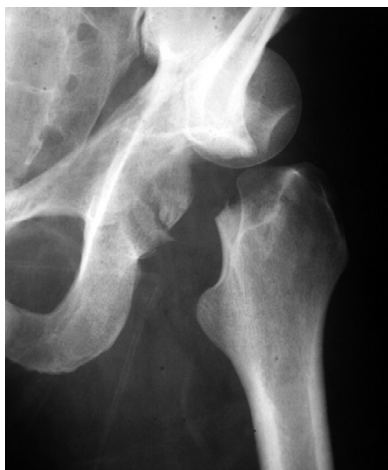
Anteroposterior plain radiograph showing the original severe fracture dislocation of the left hip prior to surgery. There is complete separation and displacement of the femoral head and femoral neck, with a fracture of the posterior wall of the acetabulum.
